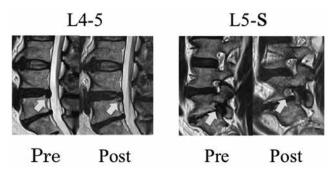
Magnetic resonance images before and after the surgery. Arrows indicate the removal of the herniated nucleus pulposus at L4-5 by the surgery. In the right para-sagittal view, arrow indicates the sufficient decompression of the right foramen at L5-S, and the right L5 nerve root is clearly confirmed.
